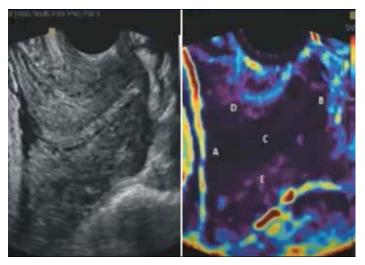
2D ultrasound and elastogram of the uterine cervix with hard cervical canal
